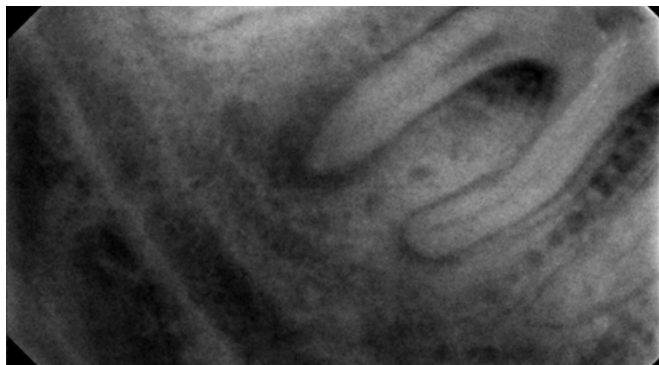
The X-ray reveals complete pulp necrosis along with inflammatory changes in the periodontal ligament and the surrounding bone.
